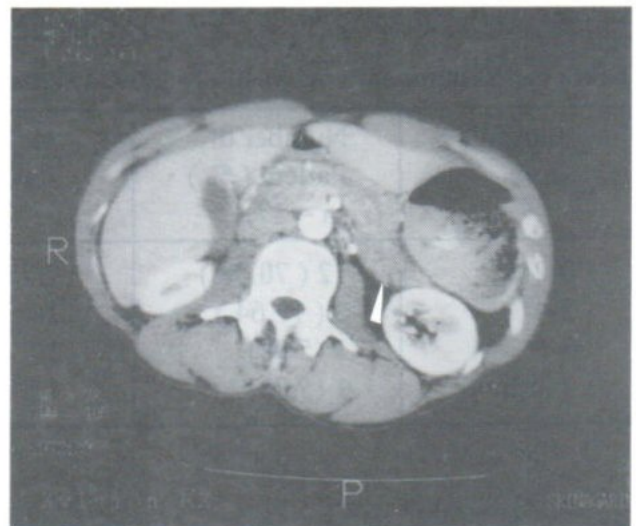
CT study showing diffuse enlargement of the pancreas without peripancreatic inflammatory changes or fluid collection (grade B).
